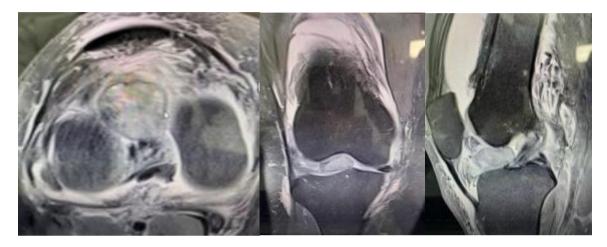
(A: Axial MRI section of the knee showing nodular image with fatty characteristics located between the distal portion of the femoral condyles, B and C: Coronal and sagittal section of MRI in which the same nodular image can be seen located between the anterior portion of the middle zone between femoral condyles and the anterior portion of the proximal tibia, anterior to the anterior cruciate ligament.)
